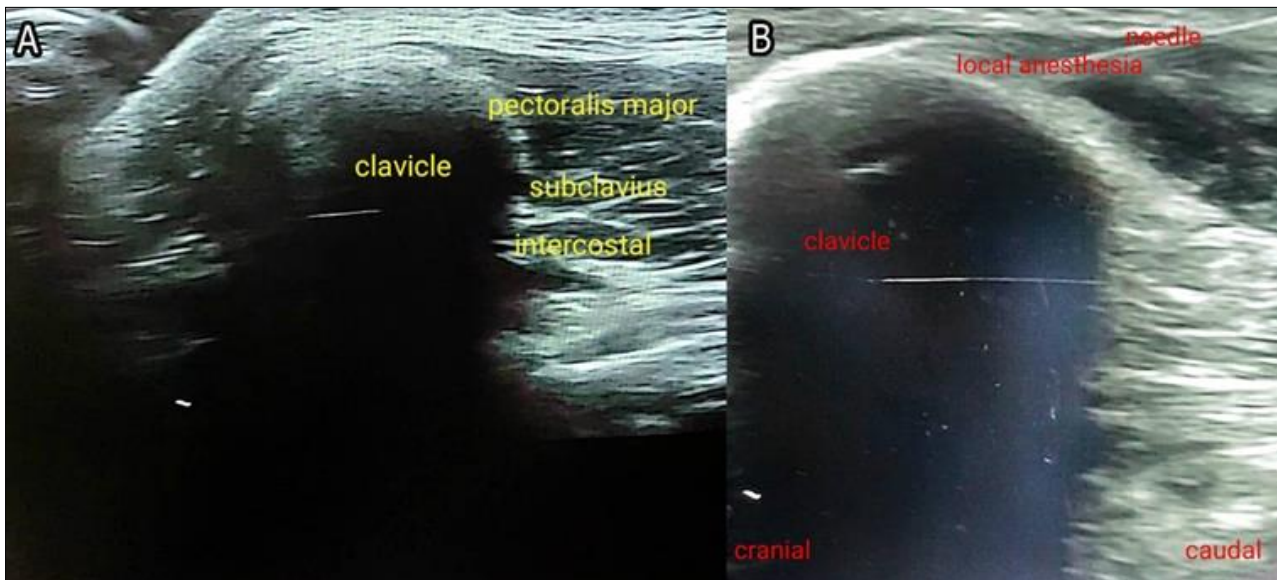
Ultrasound-guided Clavipectoral Fascia Plane Block Technique: A) Ultrasound landmarks for identifying the clavipectoral fascia; B) An ultrasound picture of the in-plane needle method for CPB.
